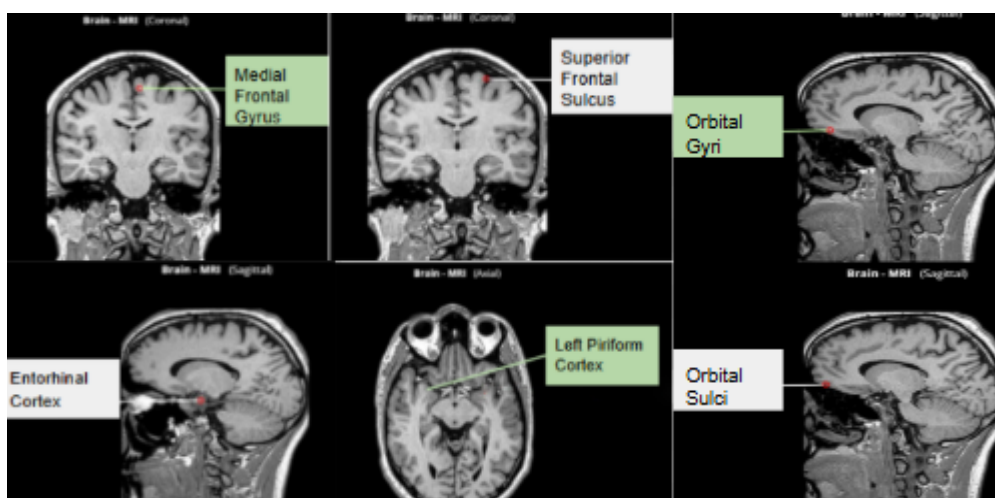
Regions of the brain associated with increased grey matter volume in congenital anosmia. Courtesy of IMAIOS © “Antoine MICHEAU, MD , Denis HOA, MD Authors' affiliations, Publication date: Aug 25, 2008, Anatomy of the brain (MRI) - cross-sectional atlas of human anatomy, <https://doi.org/10.37019/e-anatomy/163>
